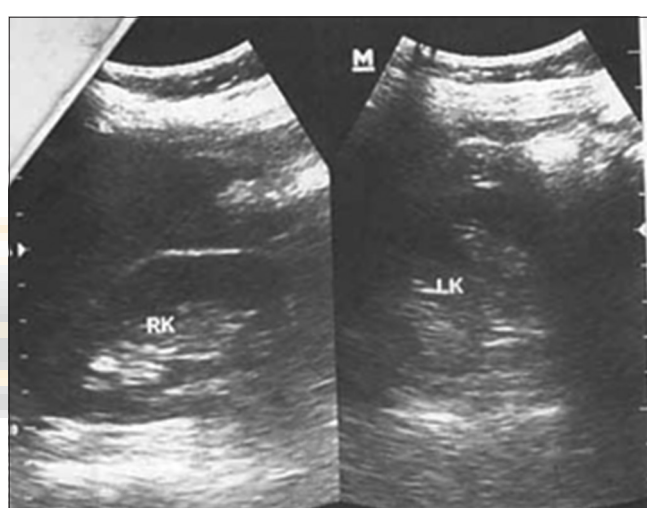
Ultrasonography kidney, ureter and bladder on December 28, 2012: No stones in the right renal pelvis and right mid ureter
